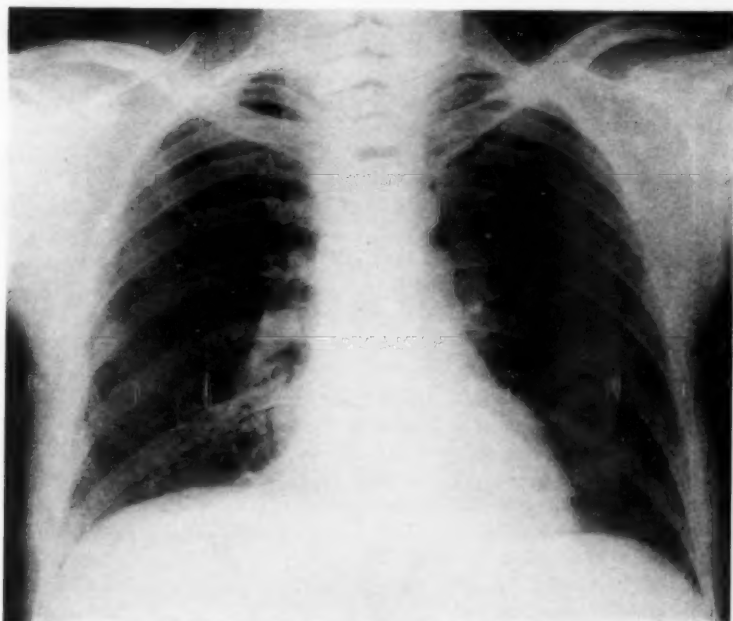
Normal chest x-ray taken on the third day of a respiratory infection.
